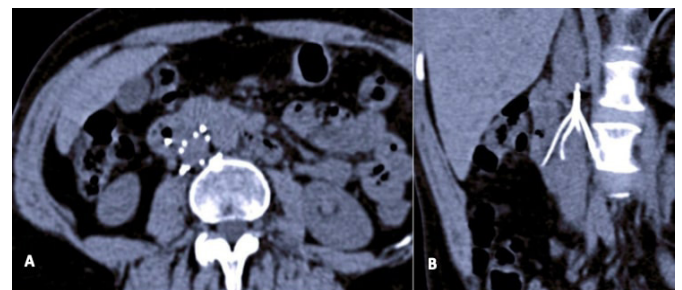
A) CT-scan showing inferior vena cava with its larger components perforating adjacent structures (duodenum, right psoas muscle and L3 vertebral body). B) CT-coronal view.
